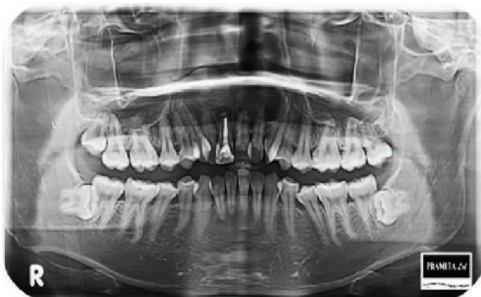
Radiograph examination shows radiolucen area on the periapical tooth 11 and 21
